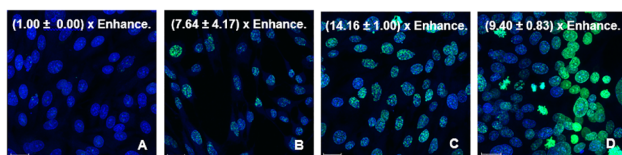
$93 \times \gamma$ H2AX (DAPI counterstain) images showing 9LGS control without radiation or treatment (A); irradiated with 5 Gy conventional X-rays (B); 5 Gy synchrotron broadbeam after IUdR + MTX treatment (C); and 5 Gy (valley dose; PVDR 10.5) MRT after IUdR + MTX treatment (D). Green represents DSB foci while blue represents cell nuclei. Average foci/cell enhancement compared to the untreated control is shown for each image.
